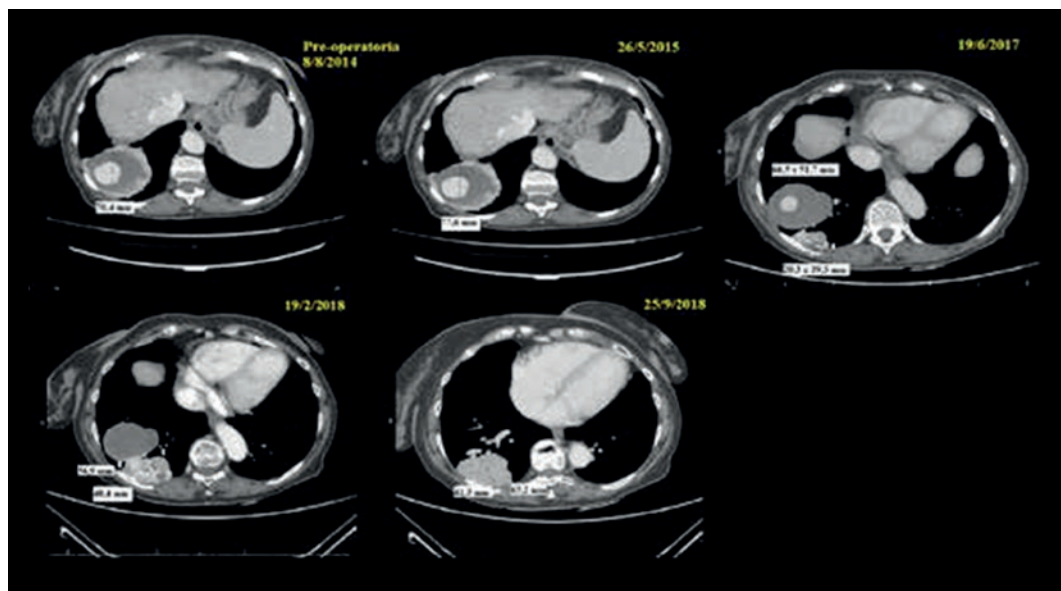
Sequence of thoracoabdominal-pelvic computed tomography scans from August 2014 to September 2018.
